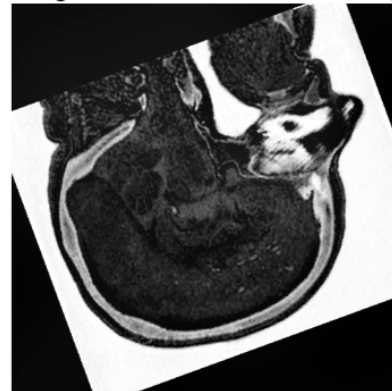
Registered unconventional CT and ZTE image in the anatomical MRI space. (a) Unconventional CT and the corresponding (b) ZTE image after preprocessing, registration, and resampling.
